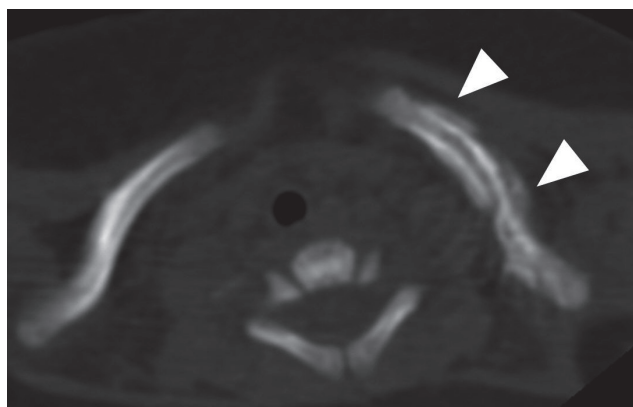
Bone setting axial computed tomography scan 2 weeks after hospitalization shows periosteal reaction (arrowheads) surrounding the left clavicle suggesting osteomyelitis.
